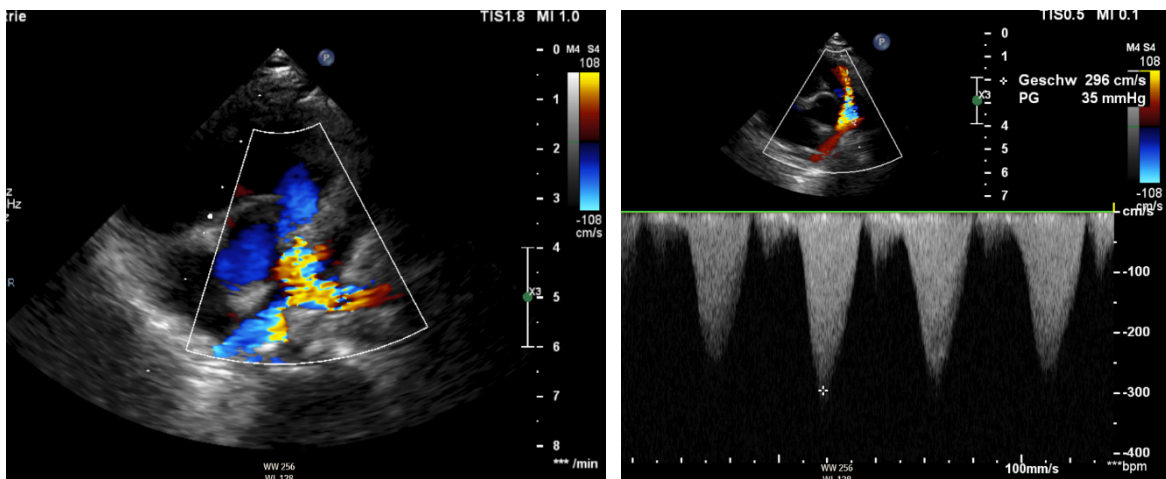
Colour Doppler (left) and CW-Doppler echocardiography (right) of severe right ventricular outflow tract stenosis. *Outpatient clinic for grown-ups with congenital heart disease, Division of Paediatric Cardiology, Department of Paediatrics, Medical University Graz*
